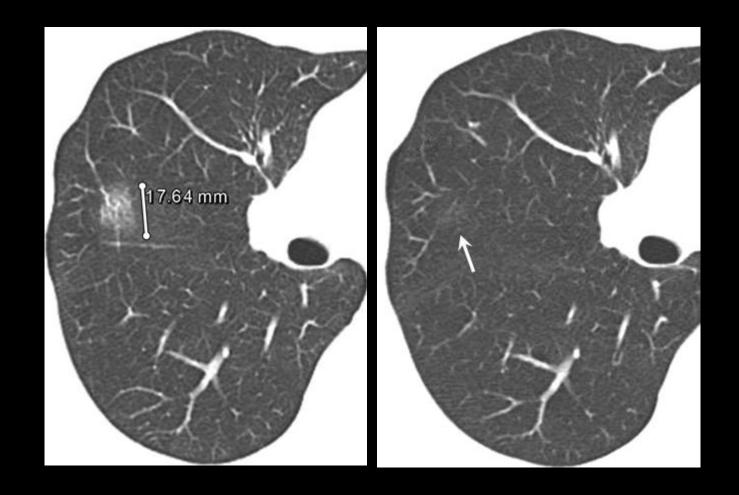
Focal inflammation mimicking adenocarcinoma. (a) Magnified 1-mm CT section through the right upper lobe shows nodules with GGO initially diagnosed as probable BAC. (b) Follow-up CT scan obtained 3 months later shows near complete resolution of the lesion (arrow), now presumed to represent focal nonspecific inflammation.
